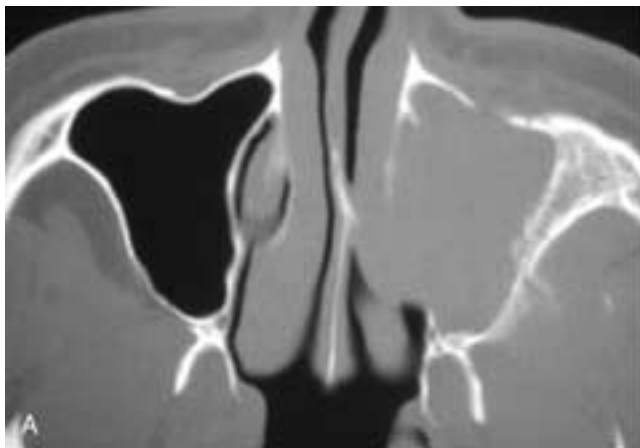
Axial CT scans (A and B) show a mass in the left maxillary sinus, with destruction of portions of the anterior, medial, and posterior sinus walls. In addition, there is an aggressive periosteal reaction in the posterior sinus wall.
